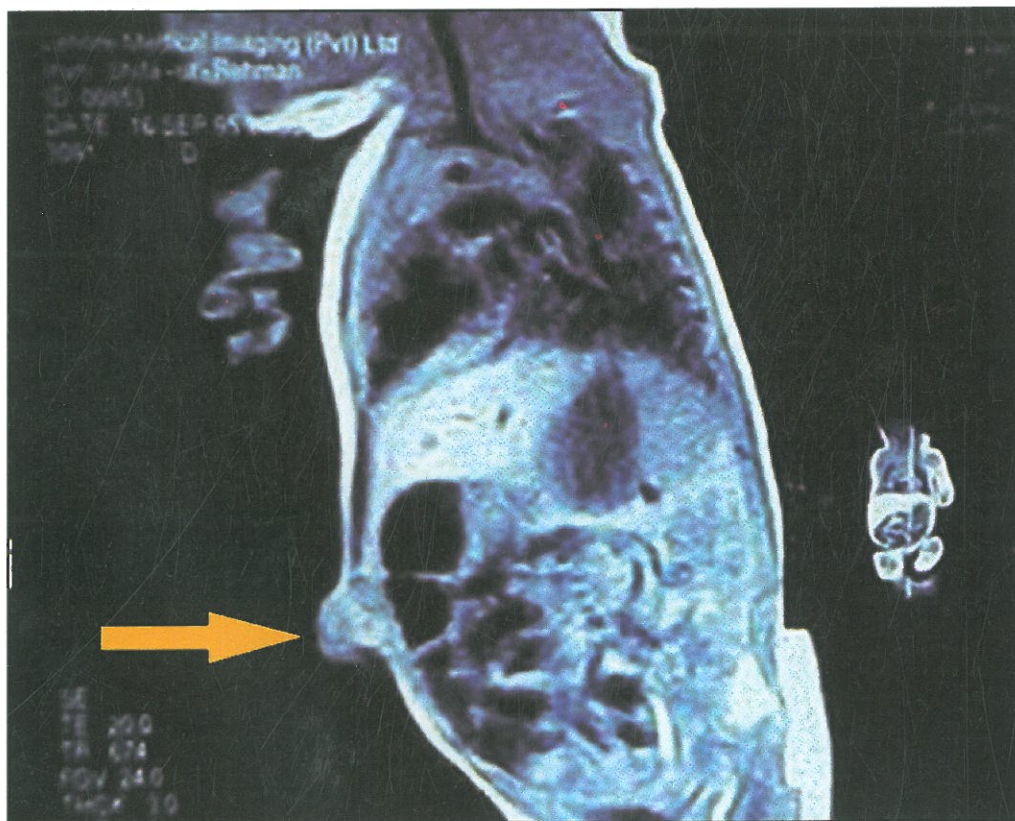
Magnetic Resonance Image Scan, showing left ventricular diverticulum extending from apex of heart up to umbilicus.
